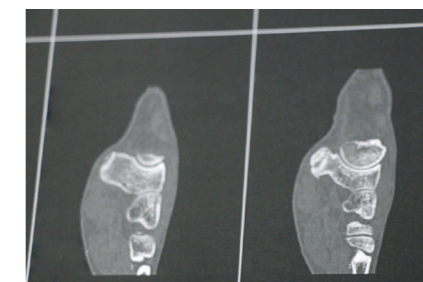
MRI of the foot showing the disunion of the accessory navicular bone from the navicular.
